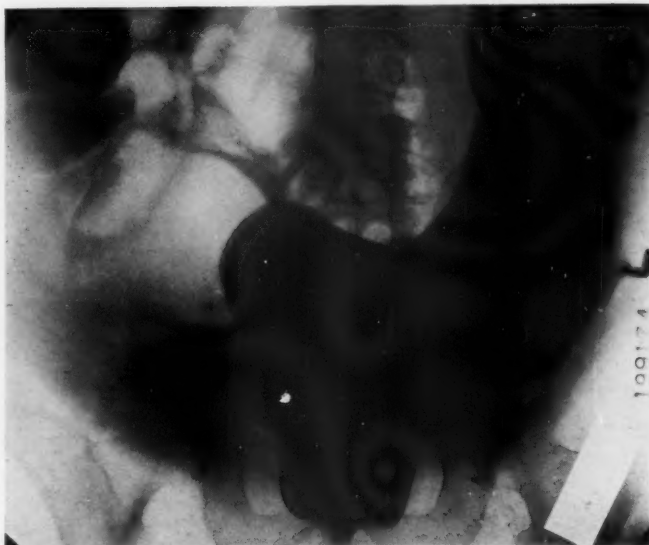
Roentgenogram of a clyisma taken on August 4, 1937. The rectum, sigmoid and lower part of the descending colon can be seen to contain barium. The outline of the cecum, part of the ascending colon, and a loop of the transverse colon are shown outlined by their contained gas.
